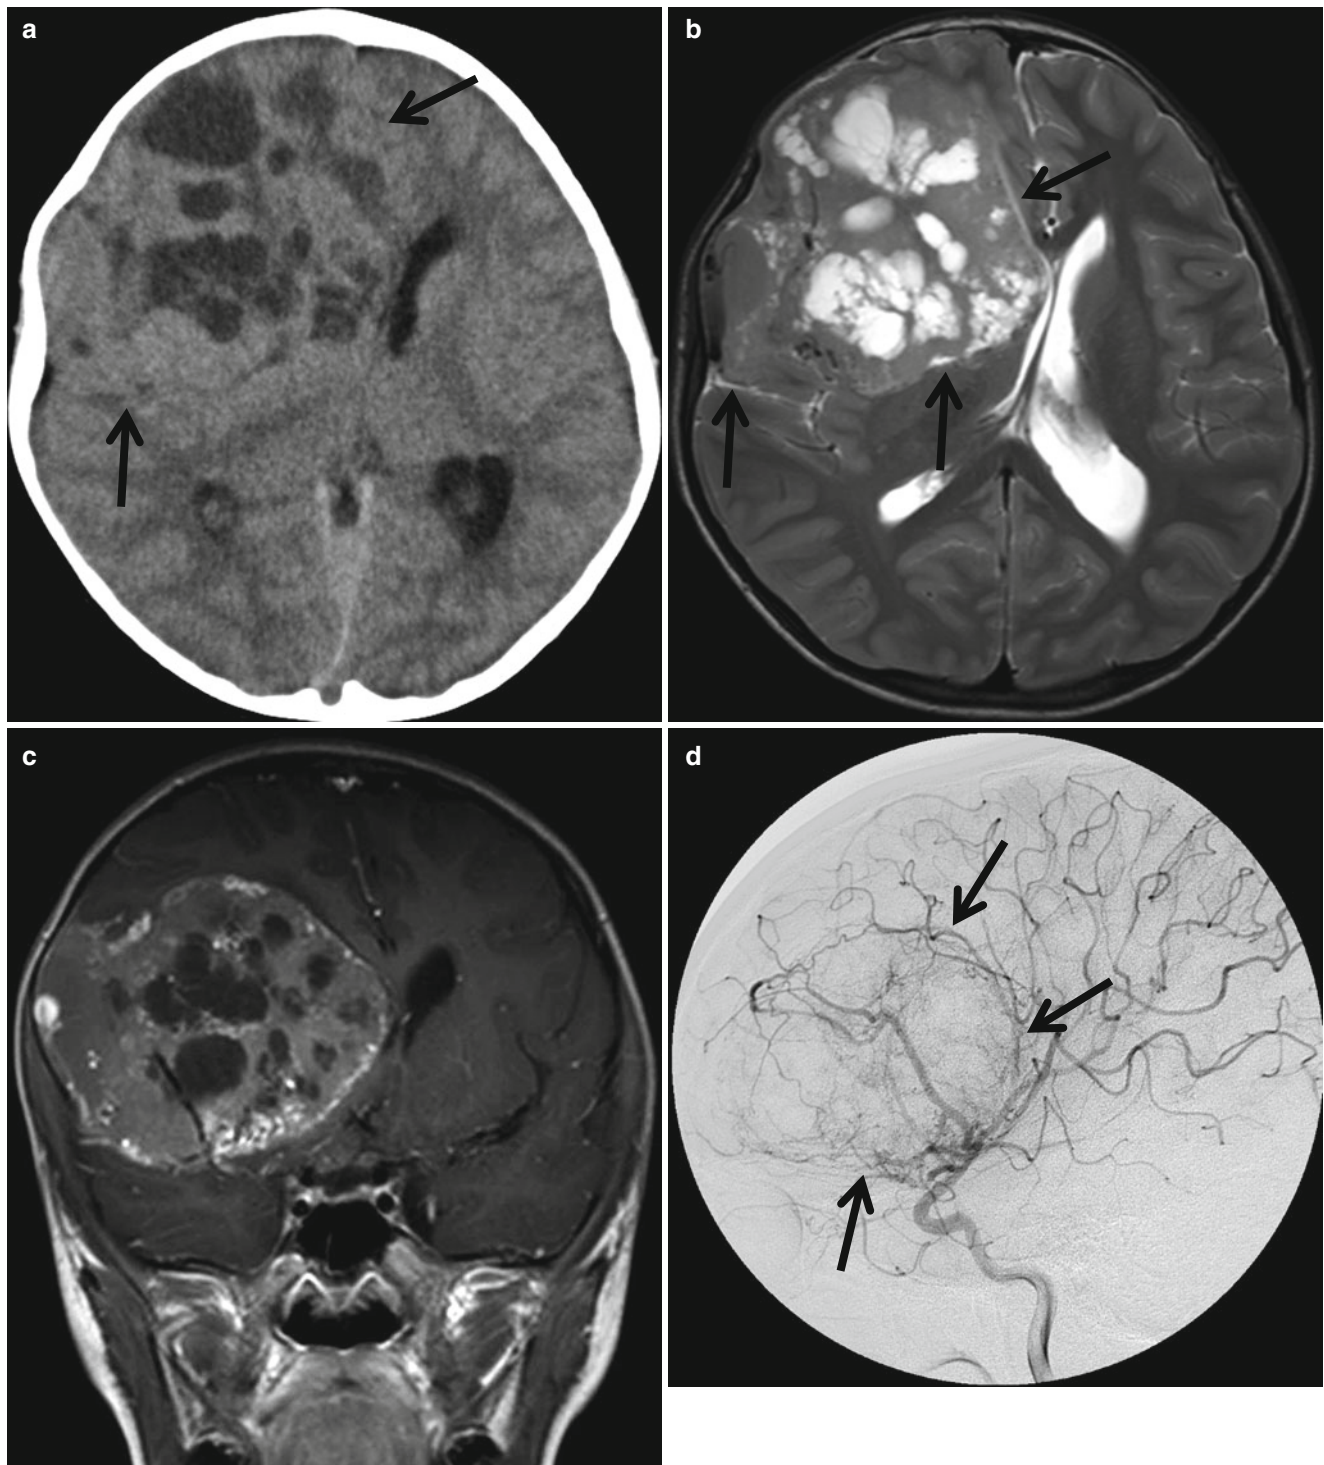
Meningioma in a 17-year-old girl. (a) Precontrast CT shows a large isodense solid mass with cystic portions (arrows) in the right frontal lobe exerting mass effect. (b) The solid portion of the mass (arrows) exhibits isointensity to the gray matter on T2-weighted image. Demarcation of the mass is clear and thin CSF cleavage lines are seen
